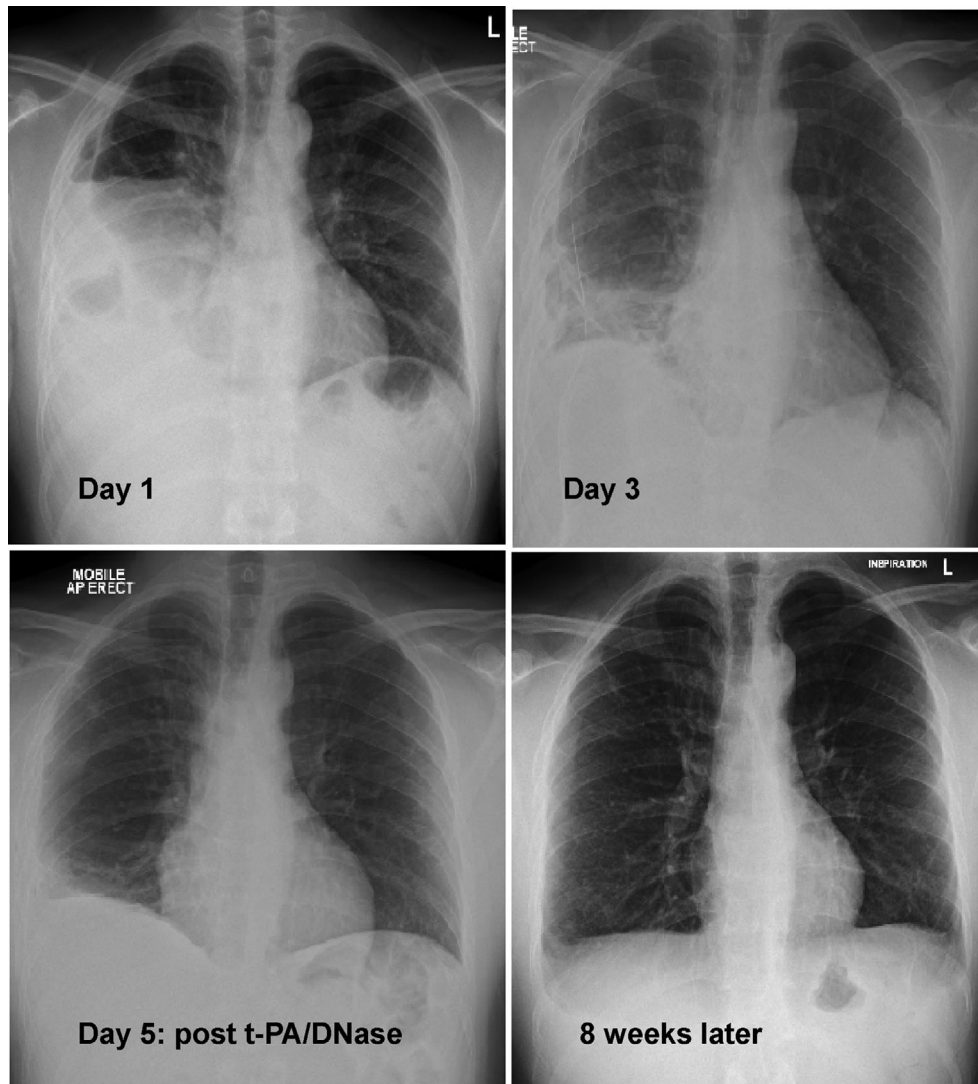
Day 1: patient attended ED and chest tube was inserted for right hydro-pneumothorax which drained 1200 mL of fluid. Day 3: Chest radiograph and bedside ultrasound confirmed residual right postero-basal loculated pleural effusion. Intrapleural tPA/DNase therapy was initiated. Day 5: Complete resolution of the right pleural effusion after two doses of tPA/DNase and removal of another 650 mL of fluid. Eight weeks later: Patient was asymptomatic with a near normal chest radiograph at follow-up.
